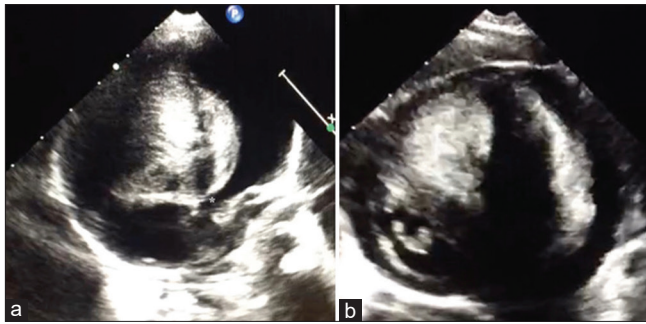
Transthoracic echocardiography. (a) corresponds to an apical 5-chamber view that revealed a giant mass (35 mm × 40 mm) located at the IVS involving the cardiac crux. The mass produces a narrowing of the left ventricular outflow tract, with a minimum diameter of 3 mm (asterisk). (b) corresponds to a posterior parasternal short axis view that shows the giant mass occupying practically all of the ventricular cavities. IVS: Interventricular septum
